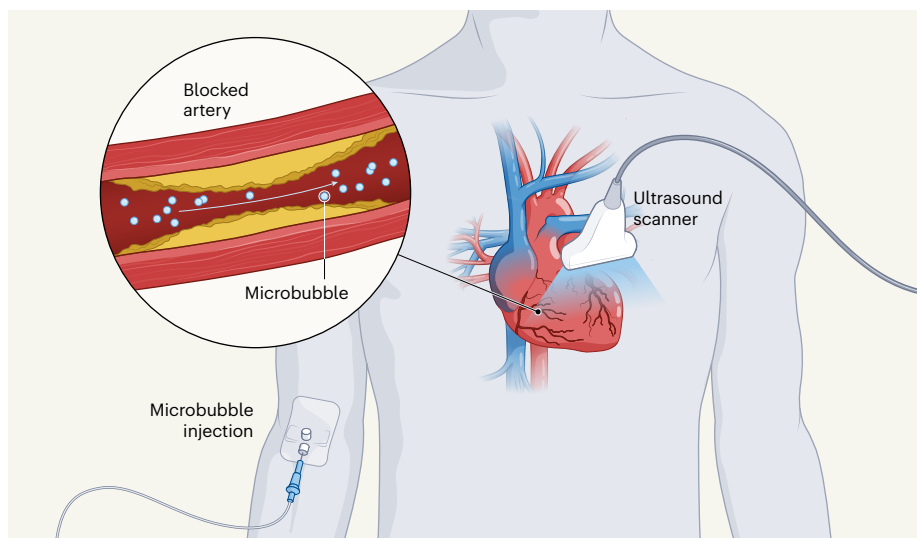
Super-resolution imaging of blood flow through the heart muscle. Yan *et al.*¹ showed that ultrasound can be used to determine the health of a person's heart muscle (myocardium) by tracking the flow of gas-filled microbubbles through the small blood vessels that perfuse the myocardium with oxygenated blood. The authors developed a way of distinguishing mobile structures from static structures, which increased the sensitivity of the method enough to enable them to verify its efficacy in clinical tests on people diagnosed with heart disease.
